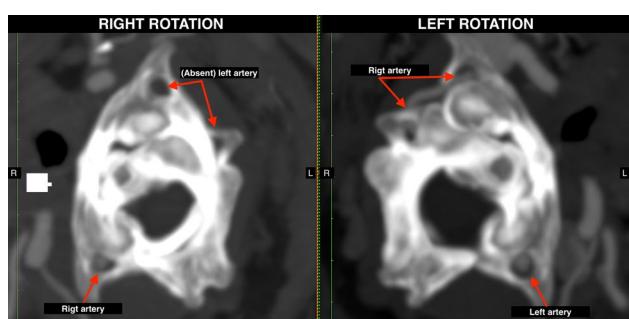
Angio-CT scan, coronal view. Left: neutral, both vertebral arteries are visible. Right: right rotation of the head produces occlusion of the left artery
